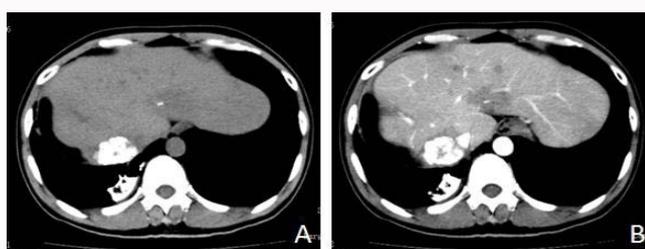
Pulmonary lipiodol embolism occurred in a patient with rHCC after TACE. (A) CT scan shows the tumor located in liver segment VII, closed to diaphragm. (B) contrast-enhanced CT scan in the same patient.
